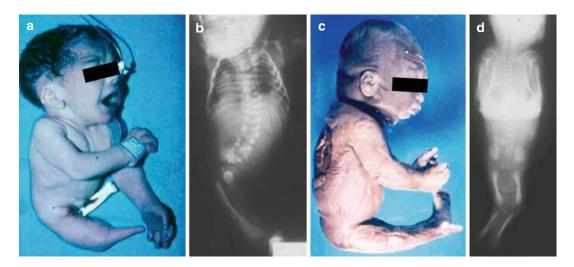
Sirenomelia [6]. Fusion of lower extremities (a) Newborn child with sirenomelia (b) Total body film showing the fusion of the lower extremities and bone abnormalites (c) Lateral view of a fetus with complete fusion of both lower extremities (d) Total body Xray of child showing both poorly developed lower extremities fused
